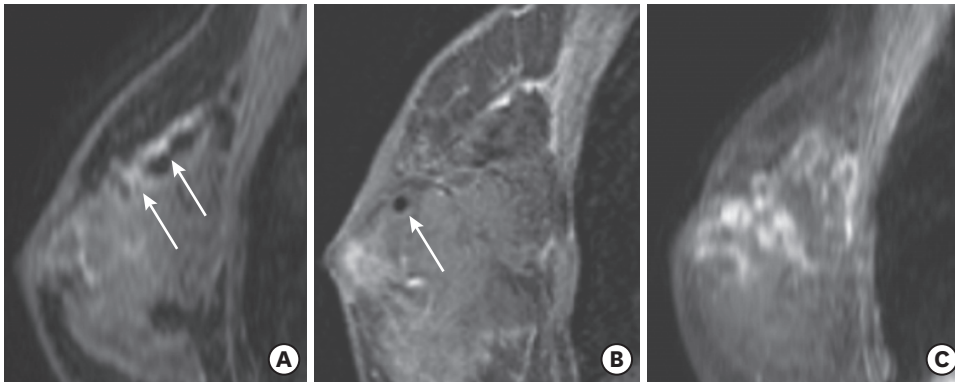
A 52-year-old woman with a discordant benign lesion on MRI-guided VAB but confirmed as IDC after surgery. (A) Sagittal T1-weighted fat-suppressed contrast-enhanced screening MR images after right breast-conserving surgery show linear non-mass enhancement in the right mid outer breast on the delayed phase image (arrows). The lesion is categorized under BI-RADS 4A. (B) On the day of biopsy, the biopsy needle was inserted into the inferior portion of the lesion (arrow) instead of its center, due to the surrounding dense fibrous scars and hardness of the breast owing to radiation-related changes. The biopsy was not thought to have been done properly, but the patient wanted a follow-up rather than immediate surgery. (C) follow-up MRI after 10 months, the lesion size increased. Surgery was done, and the lesion was revealed as an IDC. MRI = magnetic resonance imaging; VAB = vacuum-assisted biopsy; IDC = invasive ductal carcinoma; MR = magnetic resonance; BI-RADS = Breast Imaging Reporting and Data System.
